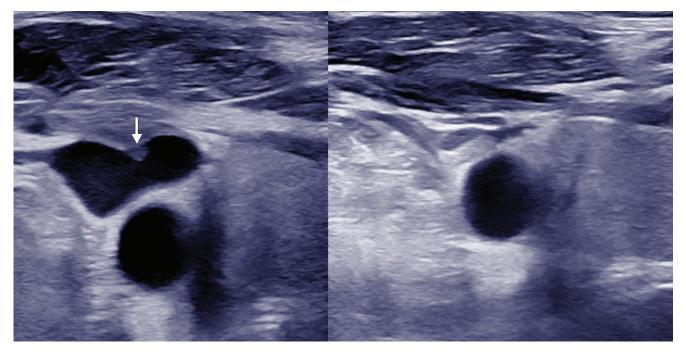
The left panel shows the right internal jugular vein with a scant amount of thrombus adherent to the anterior wall of the vessel (arrow). The right panel shows essentially complete compression of the right internal jugular vein on compression duplex ultrasonography.
